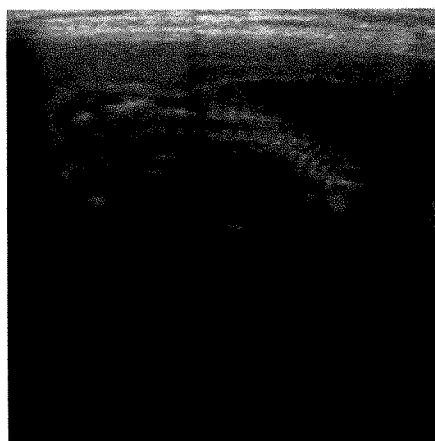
Stuck twin. Smaller of twin fetuses was relatively immobile during real-time sonography. Position of this fetus was fixed by a closely apposed amniotic membrane that was difficult to visualize.
